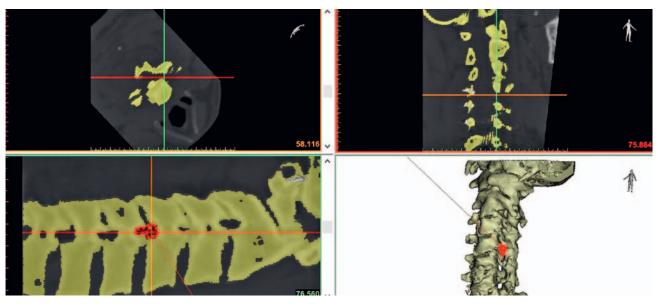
Reconstructed computed tomography scan: Cervical spine computed tomography scans reconstructed in the oblique plane viewed in Digital Imaging and Communications in Medicine format.
